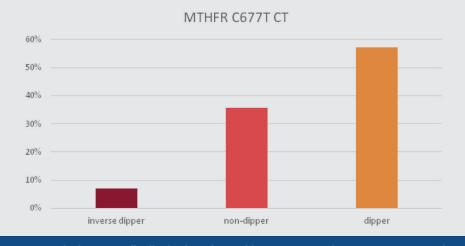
Dipping status distribution in patients with MTHFR C677T heterozygous CT mutation.
